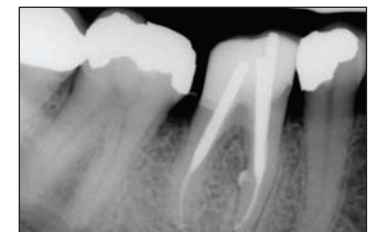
Radiographic bone fill at 6-month recall.
